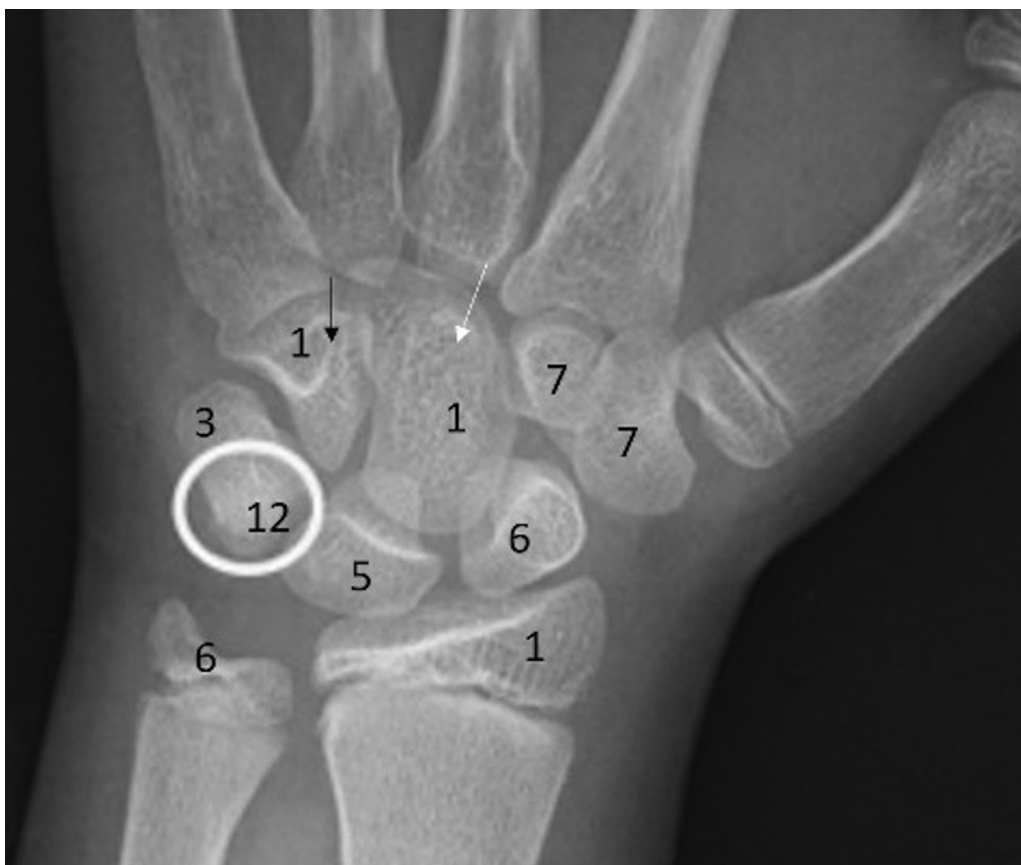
Anteroposterior radiographs of wrist joint showing the ossification center of various carpal bones. The numbers indicate the upper limit of age at which these carpal bones appear on radiograph. Capitate (white arrow) and hamate (black arrow) appear at 1 year, followed by triquetrum (3 years), lunate (5 years), scaphoid (6 years), trapezium and trapezoid (7 years), and pisiform (white circle) at 12 years.
